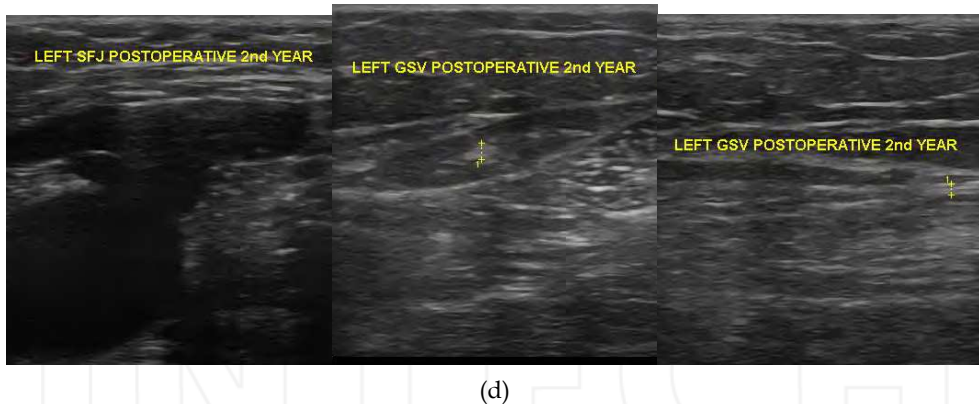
Postoperative follow-up doppler images of the same patients postoperative 1st day (a), postoperative 1st month (b) 6th month (c), 2nd year (d)
